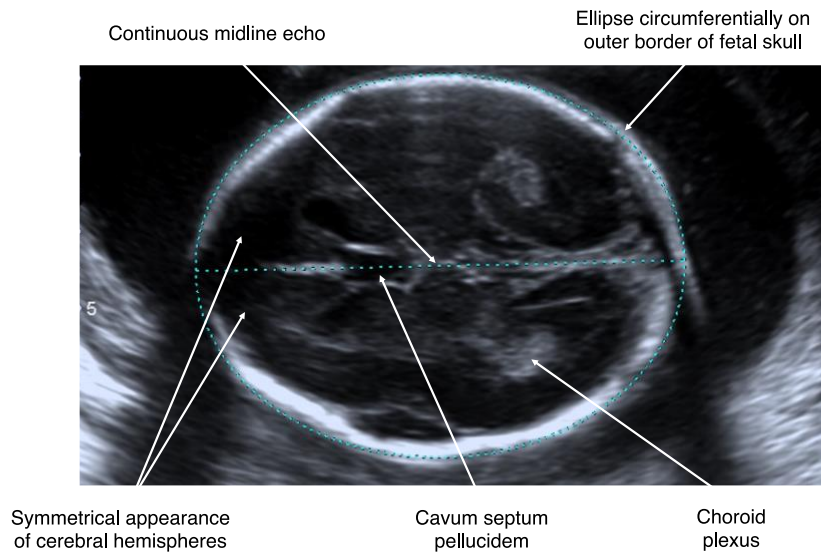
Ultrasound view required for the measurement of head circumference (HC) > 14 weeks' gestation.
